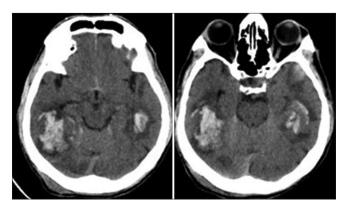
A 60-year-old male with Glasgow Coma scale 12 showing bitemporal contusions (left); repeat computed tomography showed worsening of the left temporal contusion (right). There was no change in management.
